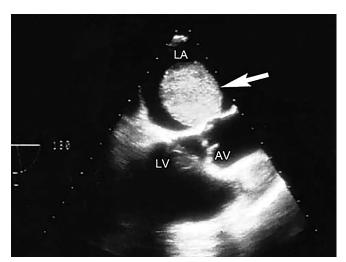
Transesophageal echocardiography. Left atrial myxoma arising from the lower part of the interatrial septum: LV left ventricle; LA — left atrium; AV — aortic valve [33]
